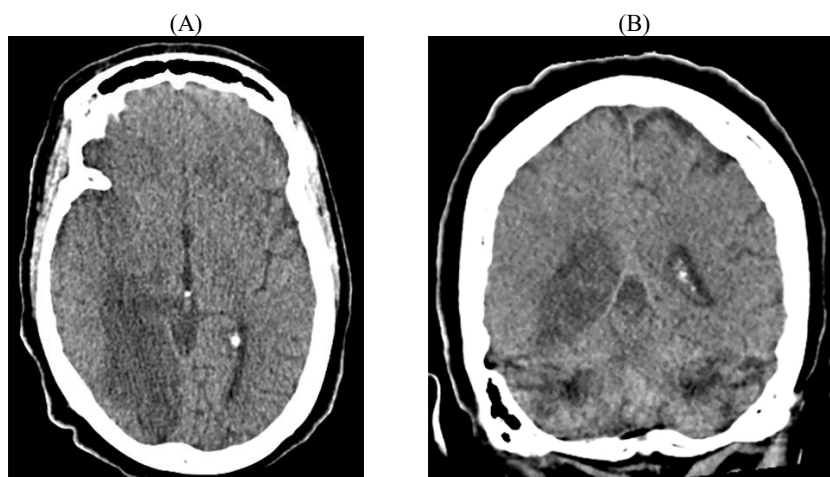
F/ 63. (A) Transaxial view, (B) Coronal view. This patient complained of a sudden onset of the left hemiplegia. Non contrast brain CT reveals an acute ischemic infarct at the right occipital and medial temporal lobe. Thromboembolism of the territory of the right PCA is the most probable cause.
